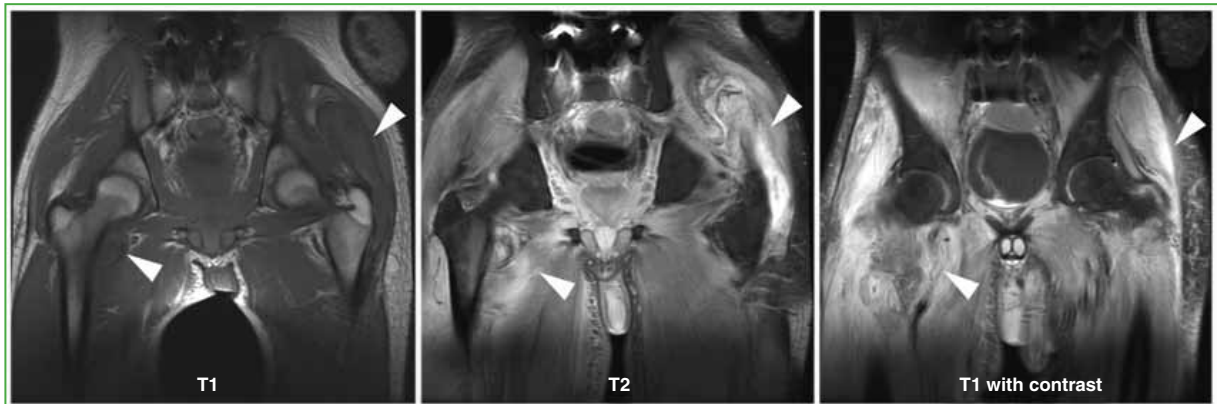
MRI of the pelvis, with contrast medium. In the T1-weighted sequence, low signal images are observed in the right lesser trochanter, with slight post-contrast enhancement. A slight edema was observed in the T2-weighted sequences. In the left gluteal region, the signal in the T1-weighted sequence is intermediate. In the T2-weighted sequence, it is high, with marked enhancement of the contrast medium.
